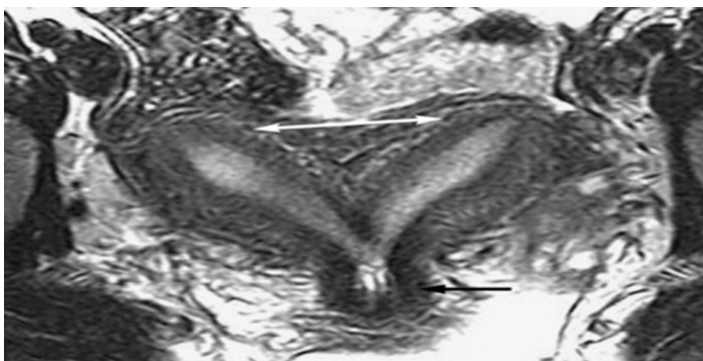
Bicornuate unicollis uterus. Axial T2-weighted image demonstrates a clefted fundus (white double-headed arrow) and single cervix (black arrow).
